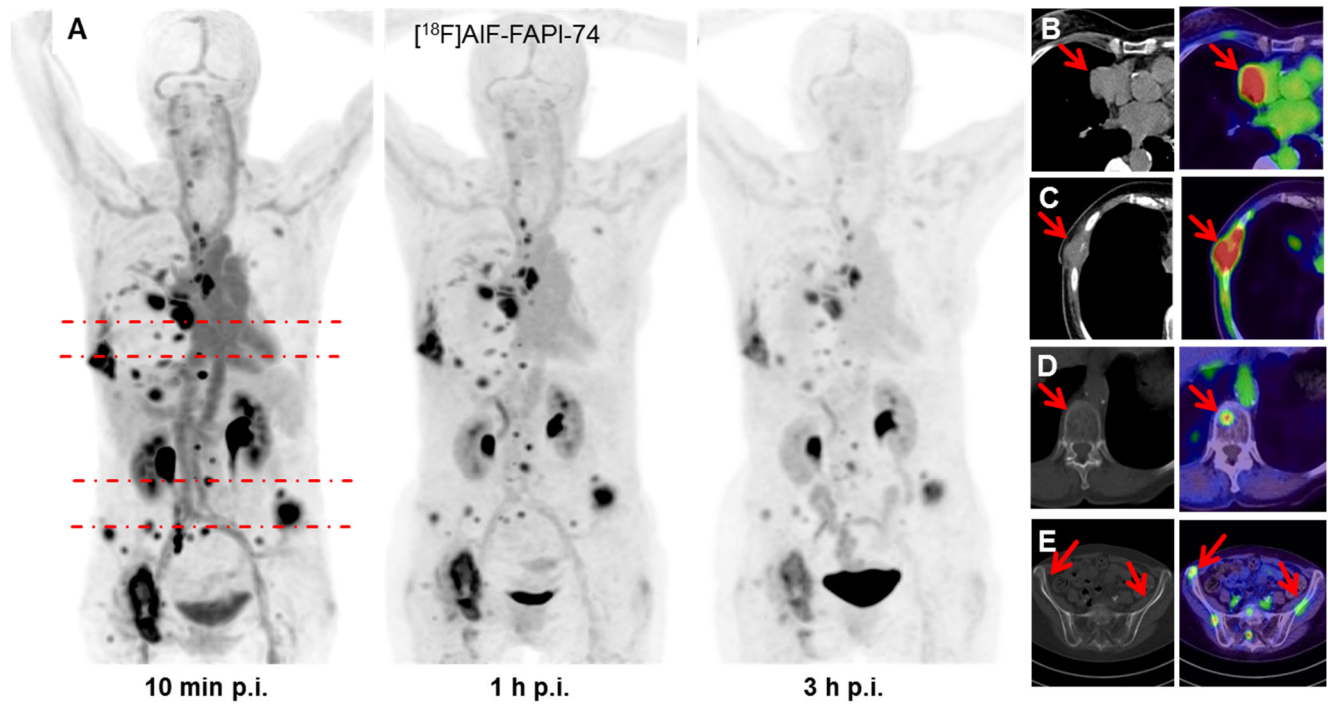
Maximum-intensity-projections of ¹⁸F-FAPI-74 PET at 10 min, 1 h and 3 h p.i. (A). FAPI-PET/CT presents favorable discrimination between tumor and myocardium (B). Some FAPI-positive lesions were confirmed by CT-correlate (C), while additional bone lesions were only detected per FAPI-PET (D, E).
